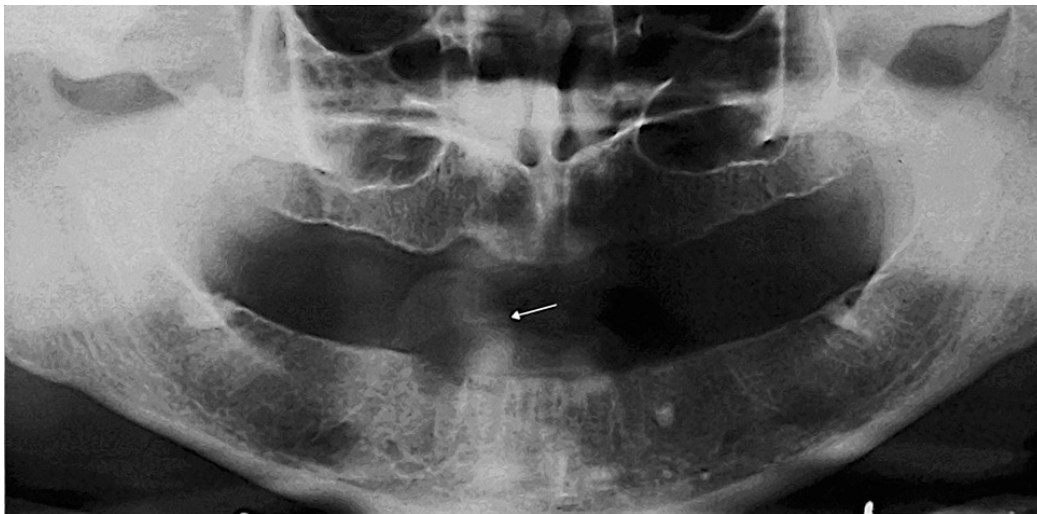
Case 19: Panoramic radiograph showing a dome-shaped soft tissue lesion (arrow) protruding from a non-healing extraction socket. The lesion was associated with erosion of the underlying alveolar cortex. The lamina dura of the extraction socket was destroyed, appearing osteolytic with poorly demarcated margins.
